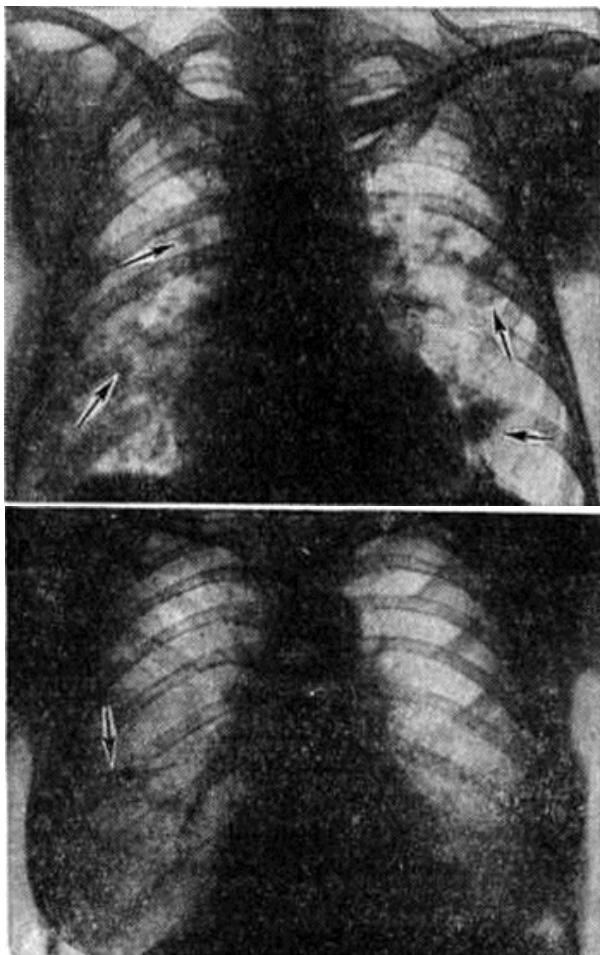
Chest X-ray of a patient with Leffler's syndrome: multiple bilateral infiltrates in both lungs (indicated by an arrow).
